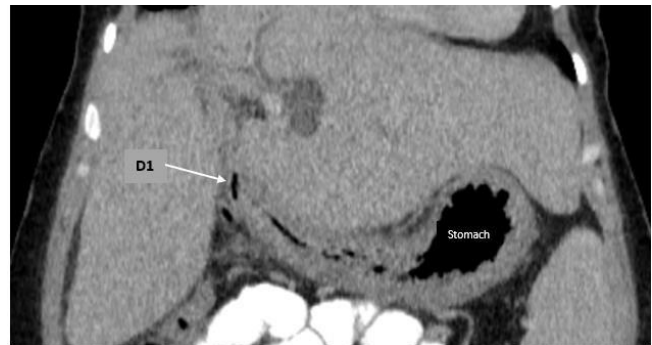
Coronal image of abdominal CT scan, revealing a tented D1 to the porta hepatis.
